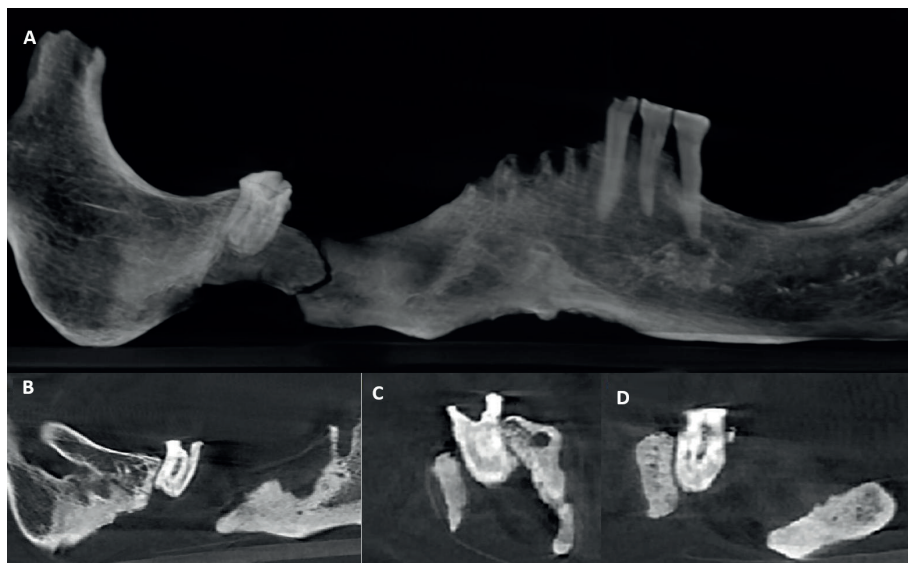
Radiographic image of the osteolytic lesion in three projections: A) panoramic reconstruction, B) oblique slice, C) coronal slice, D) sagittal slice
